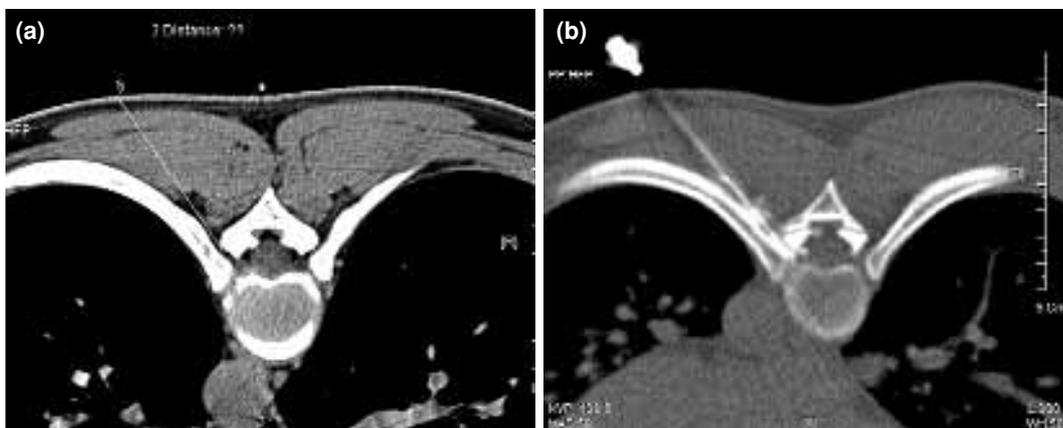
Determination of the approach route with interventional CT. (a) An imaginary line of trajectory is drawn to determine the entry point. (b) Insertion of the spinal needle into the disc space along the imaginary line under CT guidance.
